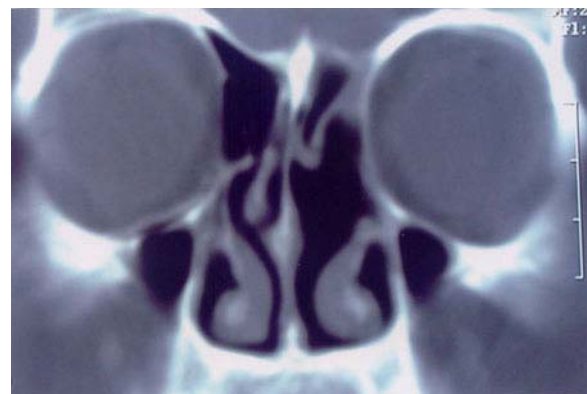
Postoperatif coronal computed tomography 6 months after surgery revealed no residual tumor
